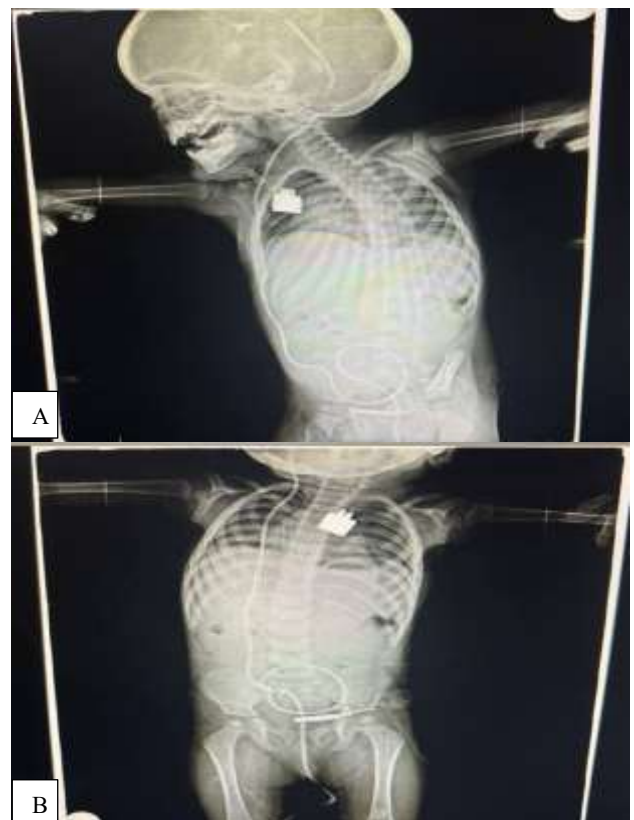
(A and B): X-ray (anteroposterior view) showing the VP shunt coursing from cranial vault to abdominal cavity with distal migration out of anus.
